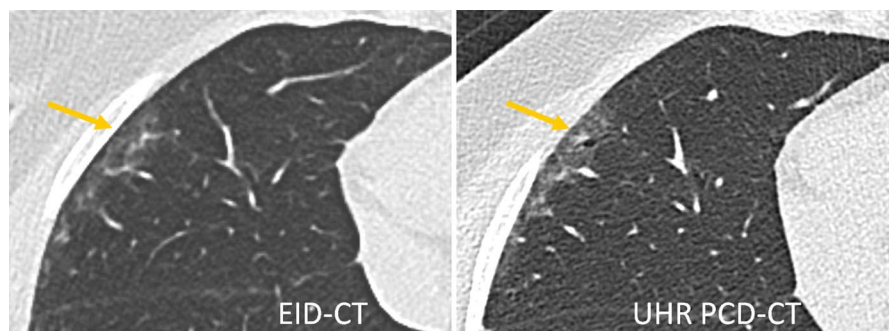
Lung scan of a patient with interstitial lung disease acquired with a third-generation DSCT (left) and a first-generation PCD-DSCT, (right). The UHR PCD-CT scan confirms the presence of traction bronchiolectasis in the periphery of the right middle lobe (arrow), superimposed on mild ground-glass attenuation. This finding was missed on the EID-CT scan. Courtesy of Dr Martine Remy-Jardin, Hôpital Calmette, Lille, France.
